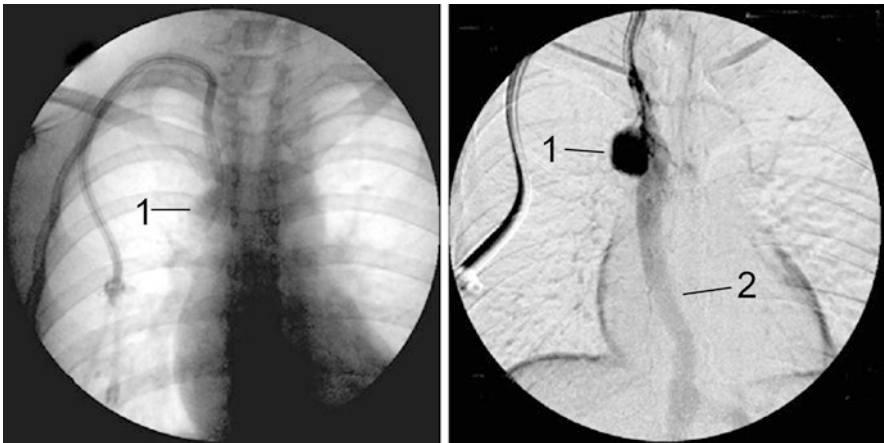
Occlusion of superior vena cava above insertion of azygos, note the nodular enlargement in the right lateral upper mediastinum in the radiograph on the left, with radiocontrast injection its identity becomes apparent (1—Arch of azygos, 2—Azygos vein)
